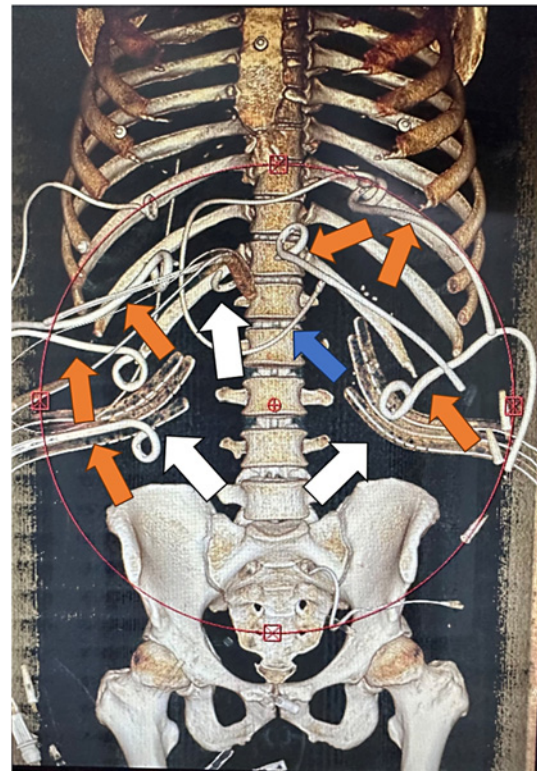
Postoperative non-contrast CT imaging, 3D reconstruction. The white arrow shows the surgical placement of the drainage tube, the orange arrow shows the B-ultrasound or CT-guided abdominal puncture drainage tube, and the blue arrow shows the jejunal nutrition tube.
